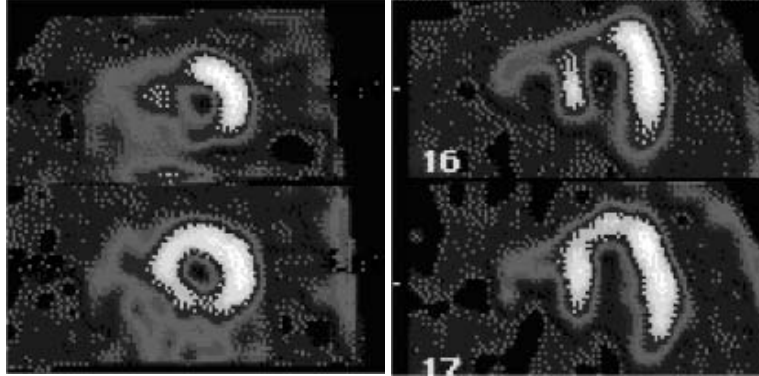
Example of a reversible perfusion defect in a cardiac SPECT study. Shown are tomographical cross-sections through the short (left) and long (right) myocardial axes. Stress images (Top) show a defect, while the rest images (Bottom) show normal perfusion.
